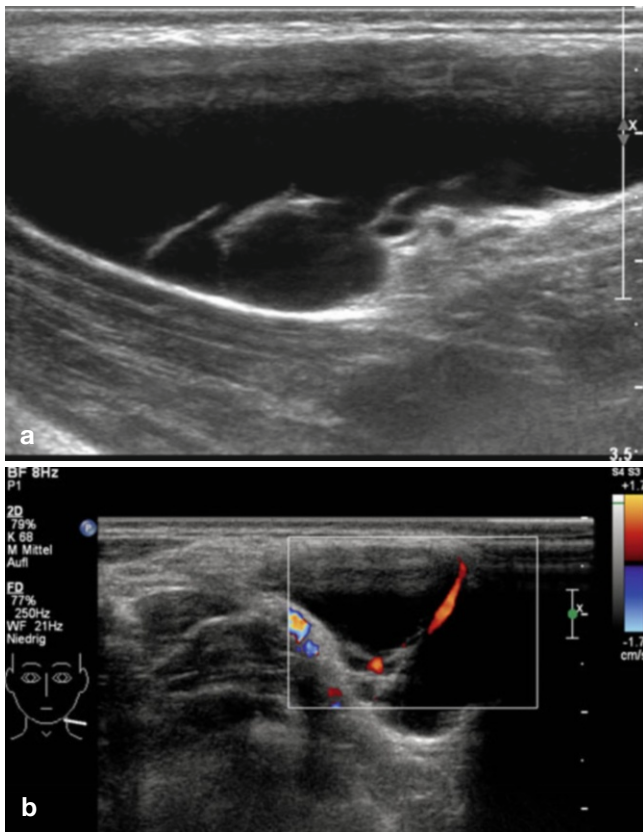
Transverse grey scale (a) and Color Doppler ultrasound images (b) of a patient with lymphangioma. A small vessel is demonstrated inside a thick septum (b) in this otherwise avascular lesion
